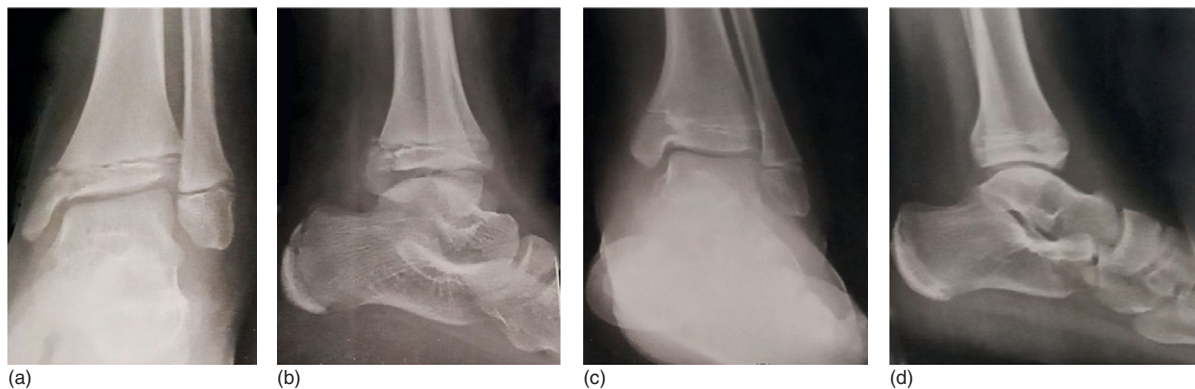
Radiographs left ankle fracture (a) anteroposterior (b) lateral immediately after fracture (c) anteroposterior and (d) lateral at 6 months
